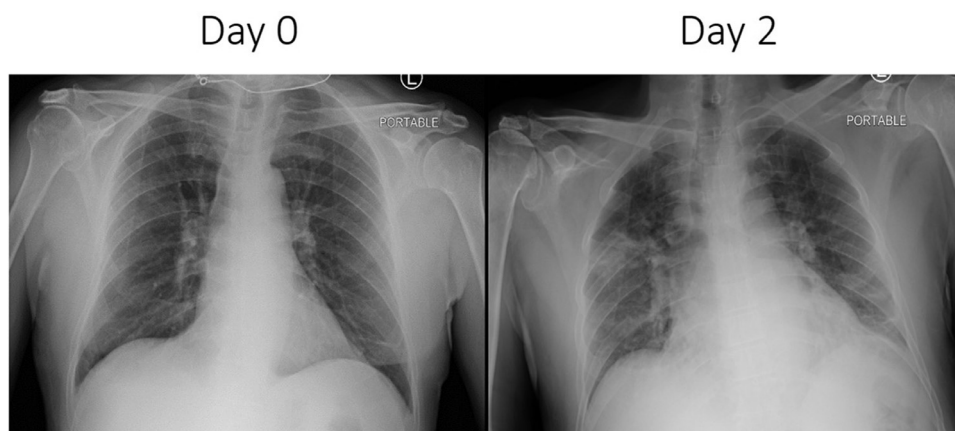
Chest X-Ray, Portable AP view 3/29 (left) and 3/31 (right). Note the marked difference in opacification from initial ED presentation (within normal limits) and return two days later (diffuse multifocal pneumonia).
